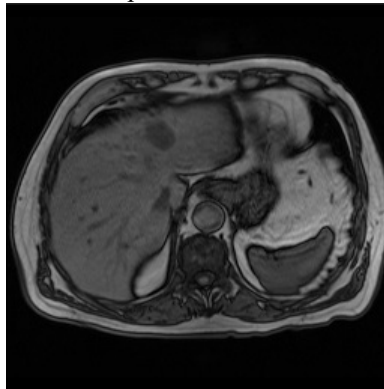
Represented one slice of Patient MRI scan image with Cancerous region.
